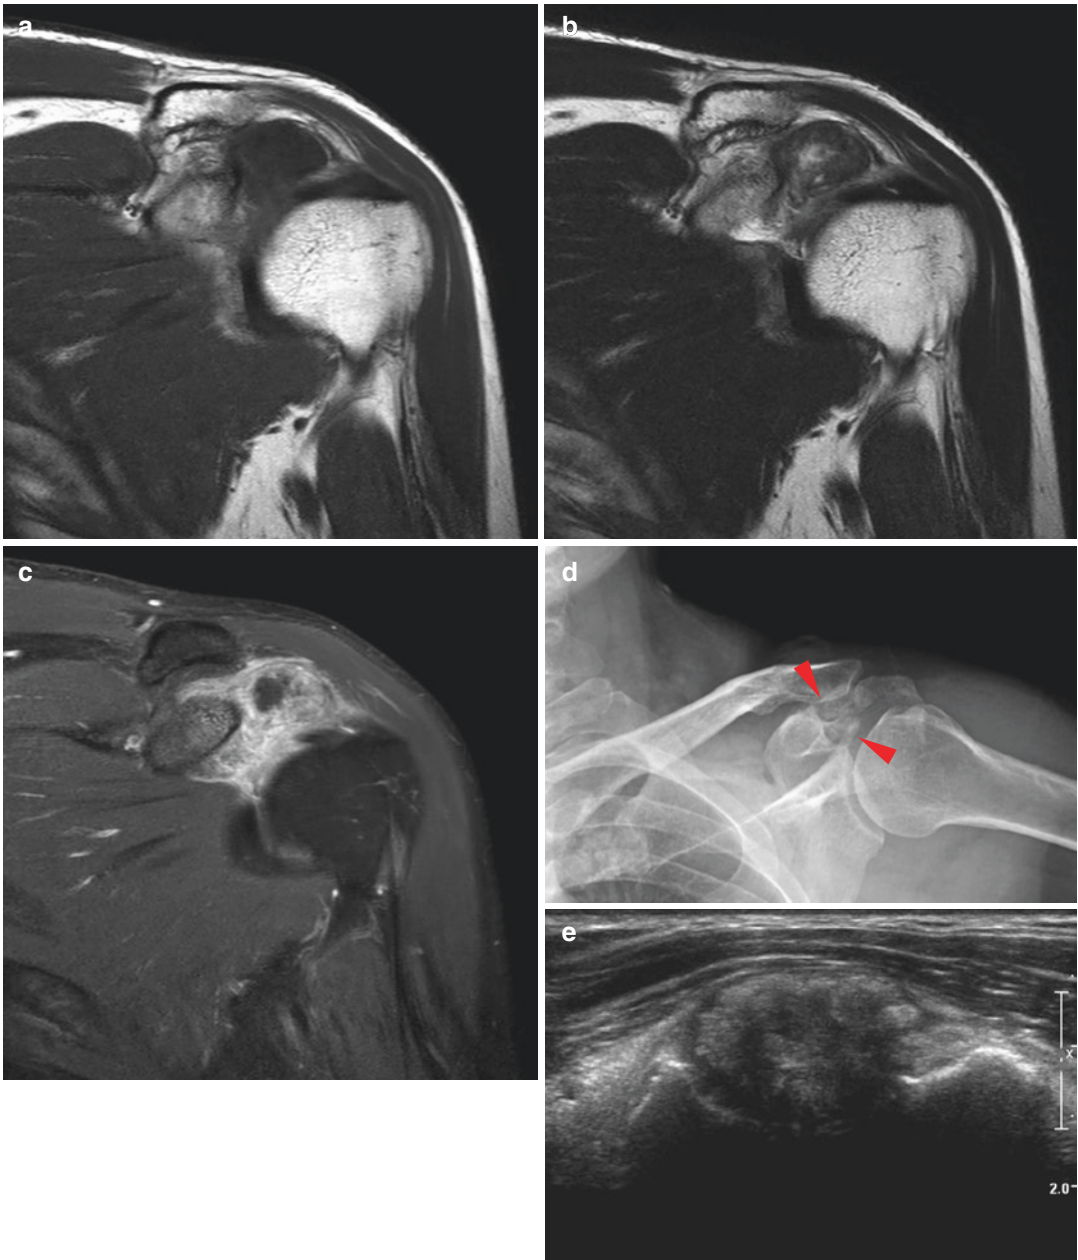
Gout. MR images (a–c) shows a mass in the left shoulder. On coronal T2WI (b), the mass shows heterogeneous signal intensity, predominantly intermediate to low. The mass demonstrates heterogeneous enhancement with central cavitation on postcontrast FS T1WI (c).
